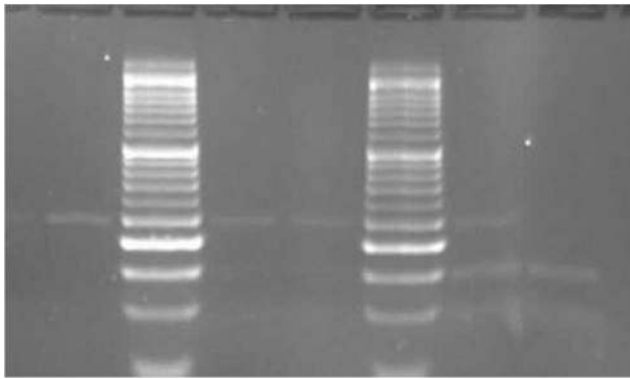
PCR product electrophoresis photograph related to the SIRT1 rs3758391C/T polymorphism after PCR–RFLP. Sample 1: TT; samples 2 and 3: CT; samples 4 and 5: CC. The ladder was 50 bp
